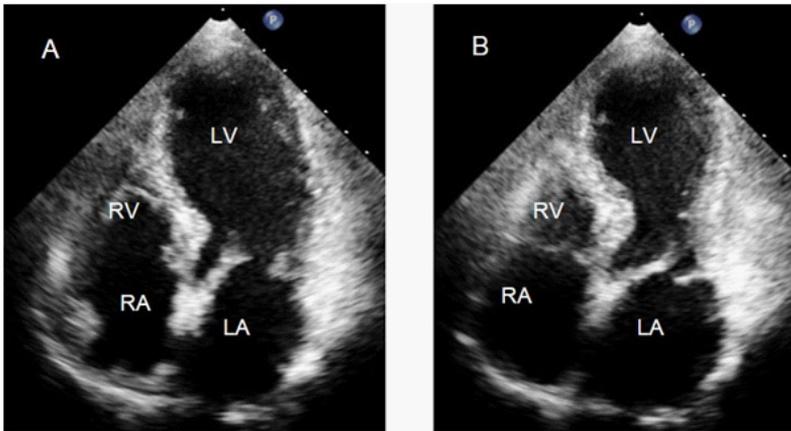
Apical ballooning Tako Tsubo. Trans-thoracic echocardiography allows to assess the typical left ventricular contractile pattern showing, during systole (panel B), the akinesia or hypokinesia of mid and apical segments with the normal or visual hyperkinesia of basal segments. Panel A: diastole. Panel B: systole. LA: left atrium. RA: right atrium. LV: left ventricle. RV: right ventricle.
